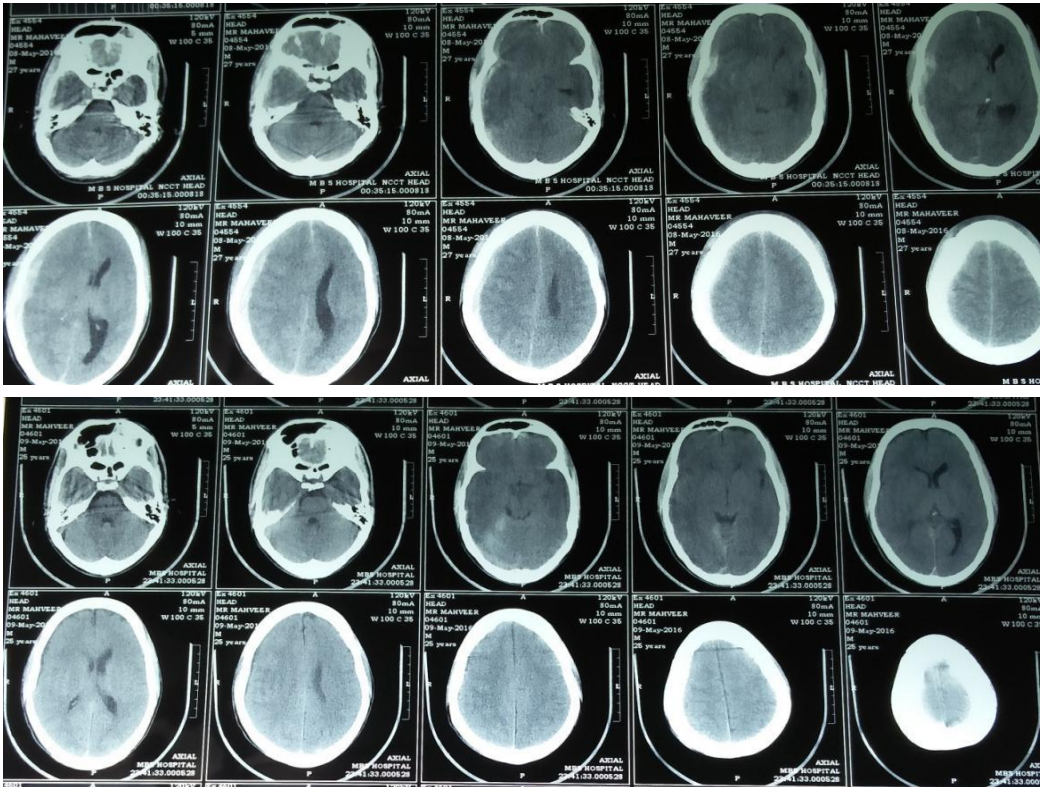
(A): Head CT Scan shows large right temporoparietal SDH with midline shift.
